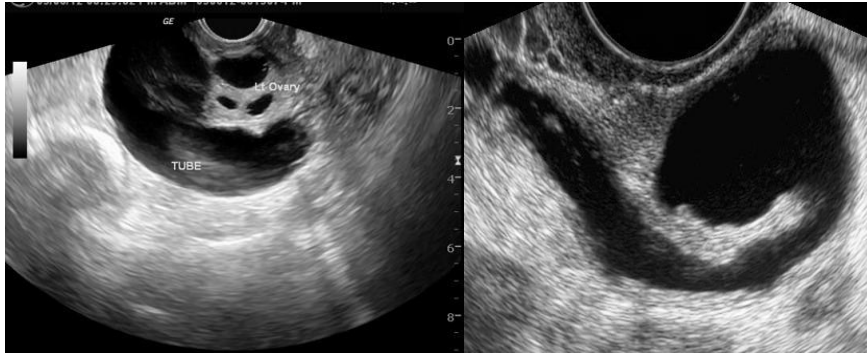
Ultrasound image for hydrosalpinx (Steinkeler et al, 2009)
